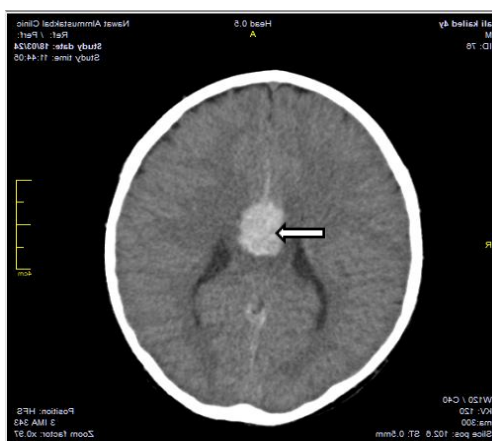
Brain CT showed a smaller hematoma on the corpus callosum, compared to the previous CT image
